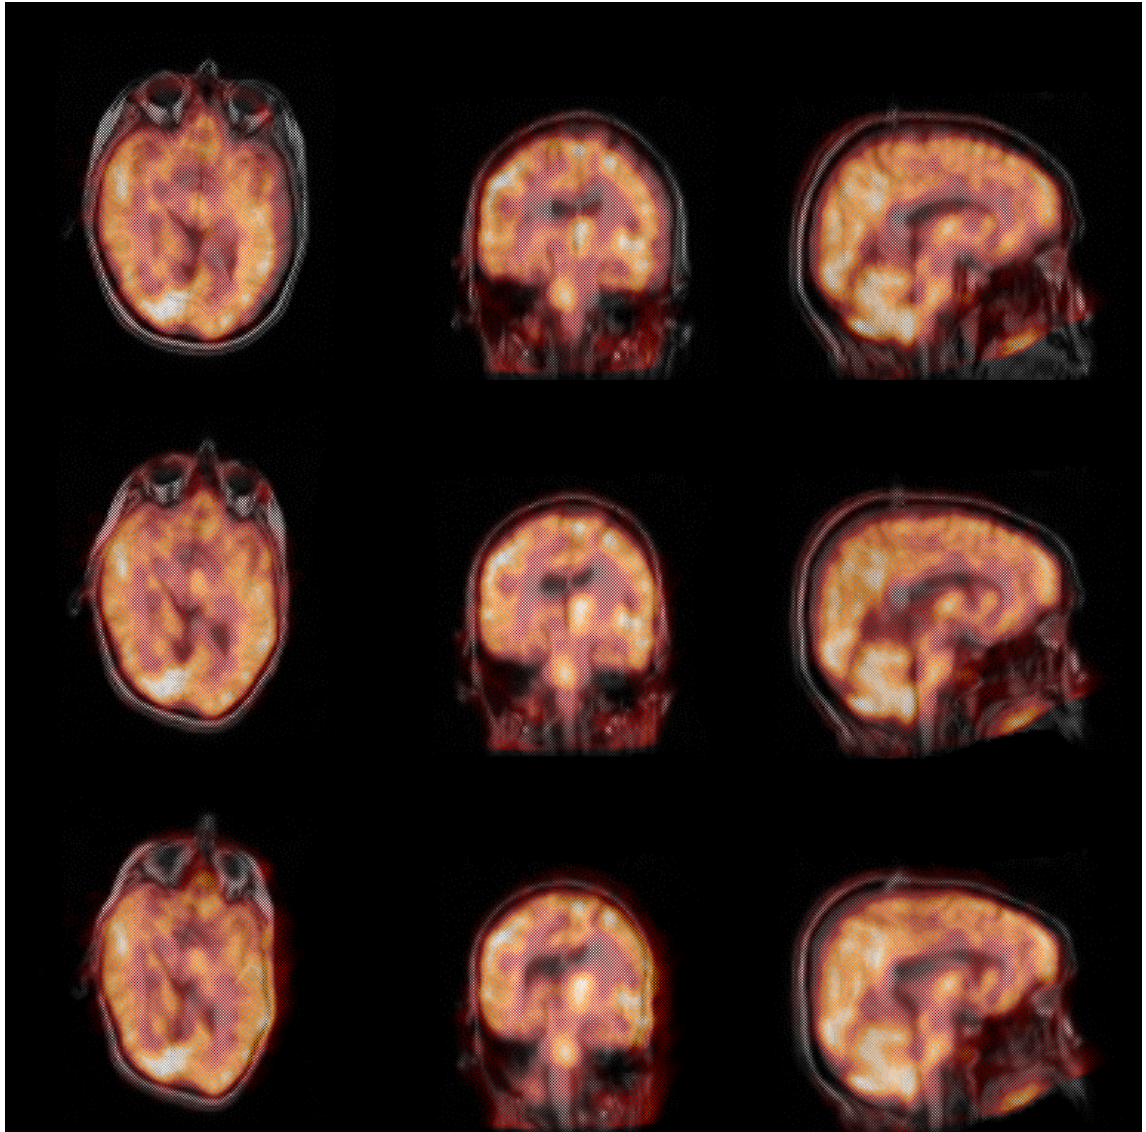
The results of SPET-MR 3D registration using default implementation. Shown from left to right, are the transverse, coronal and sagittal sections. The SPET and the MR images are first globally registered using a rigid-body transformation and the transformation applied to the SPET image. Reference image (SPET), rendered in ‘red temperature’ scale, overlays a grey scale image representing (top) the floating MR image before registration, (middle) the non-rigidly registered floating image, and (bottom) the correctly transformed floating image. Note that it is difficult to distinguish between these two cases.
